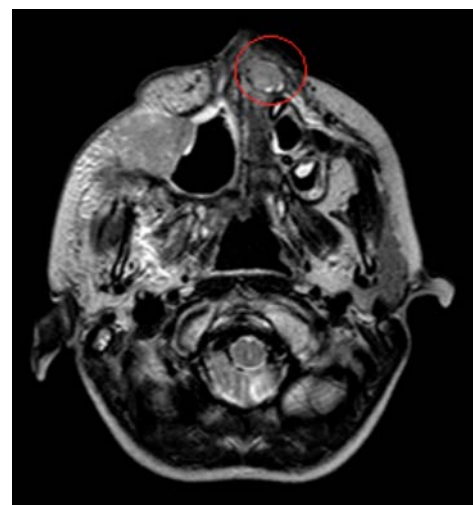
Magnetic resonance imaging demonstrating known right-sided disease and progression during treatment (red circle).
